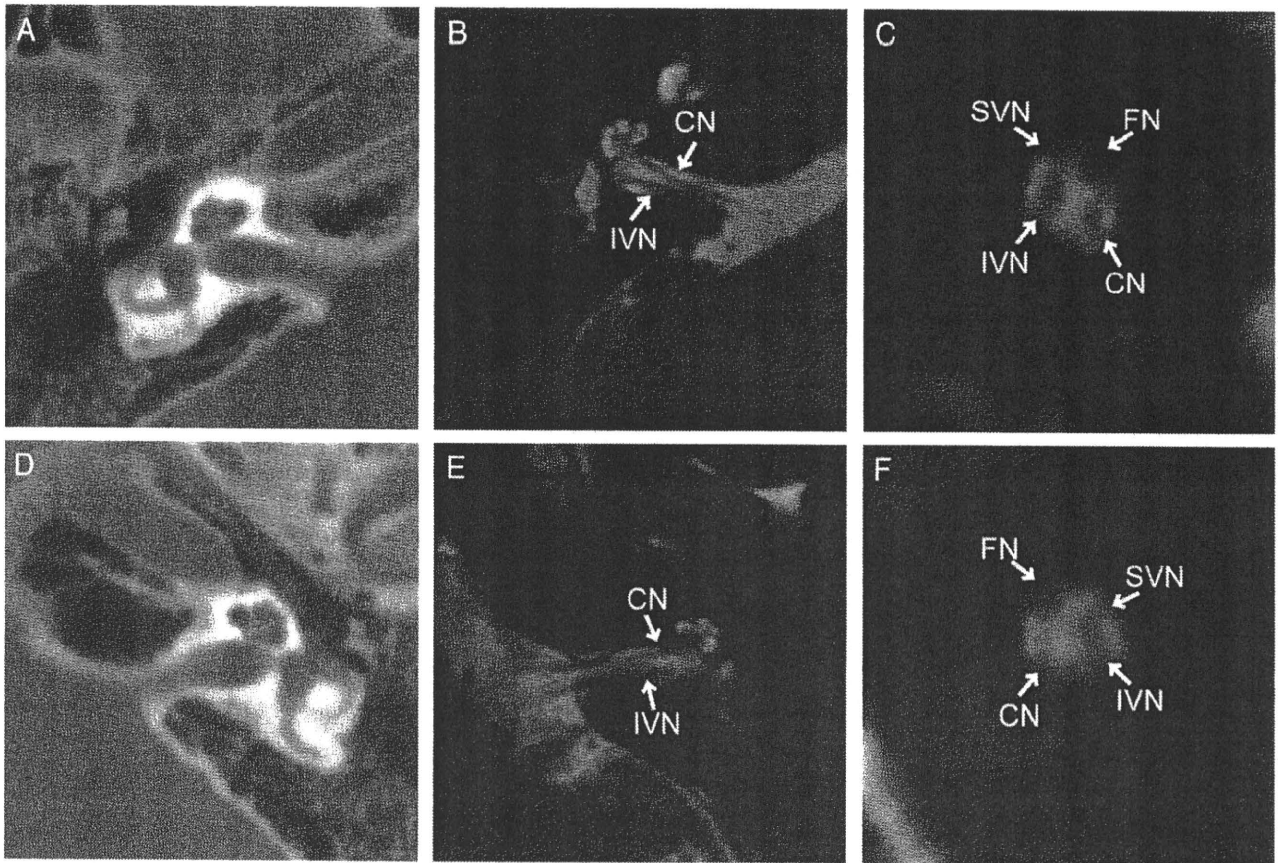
Images showing the HRCT (A, D), axial MRI (FIESTA: B, E), and oblique sagittal reconstructions (C, F). The facial nerve (FN), cochlear nerve (CN), superior vestibular nerve (SVN), and inferior vestibular nerve (IVN) can be recognized in both sides of the internal auditory canal. However, the cochlear nerves in both ears were narrower than the vestibular nerves in axial FIESTA slices. Moreover, the cochlear nerves on both sides were smaller than the adjacent facial nerves in oblique sagittal reconstructions.
